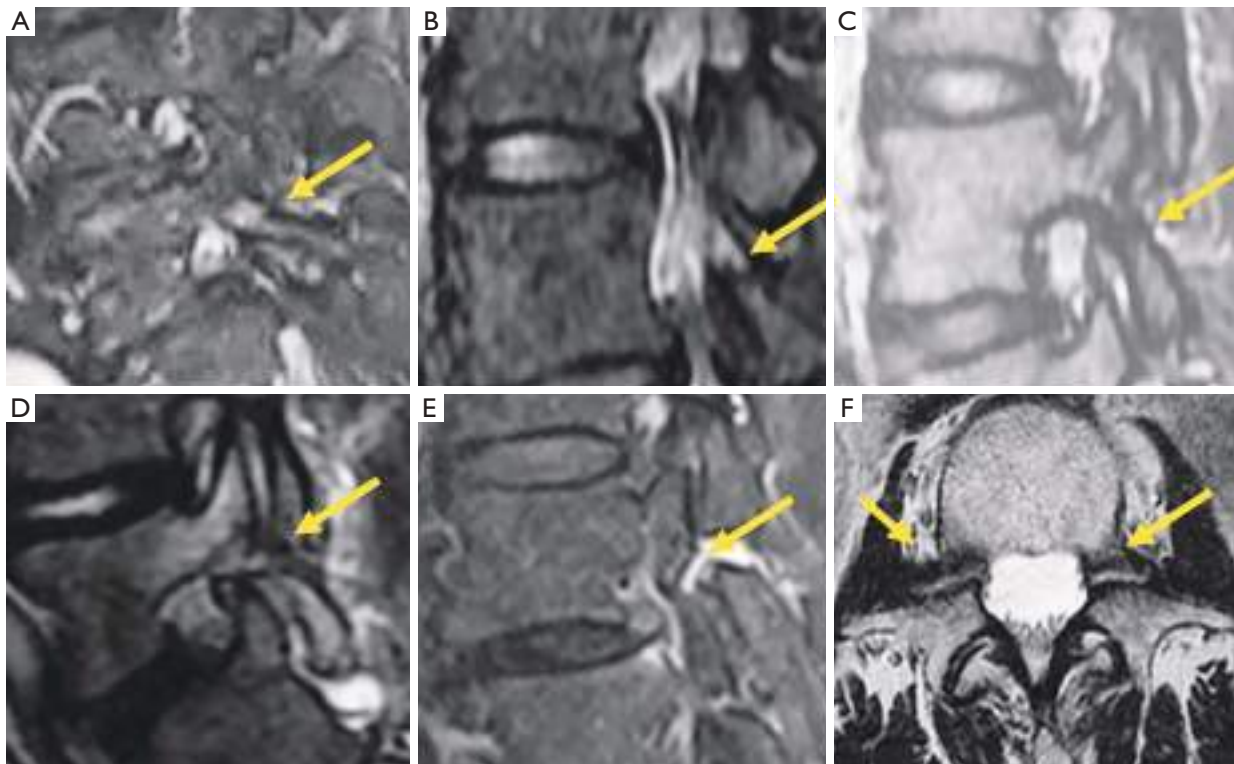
MRI of spondylolysis. (A) Sagittal STIR image of grade 1 spondylolysis showing edema without pars interarticularis defect (arrow). (B) Grade 2 spondylolysis, partial defect with edema (arrow). (C) Grade 2A spondylolysis, partial defect without edema (arrow). (D) Grade 3 spondylolysis, complete defect with edema (arrow). (E) Grade 4 spondylolysis, chronic defect without edema (arrow). (F) Bilateral pedicle spondylolysis (arrow). MRI, magnetic resonance imaging; STIR, short tau inversion recovery.
